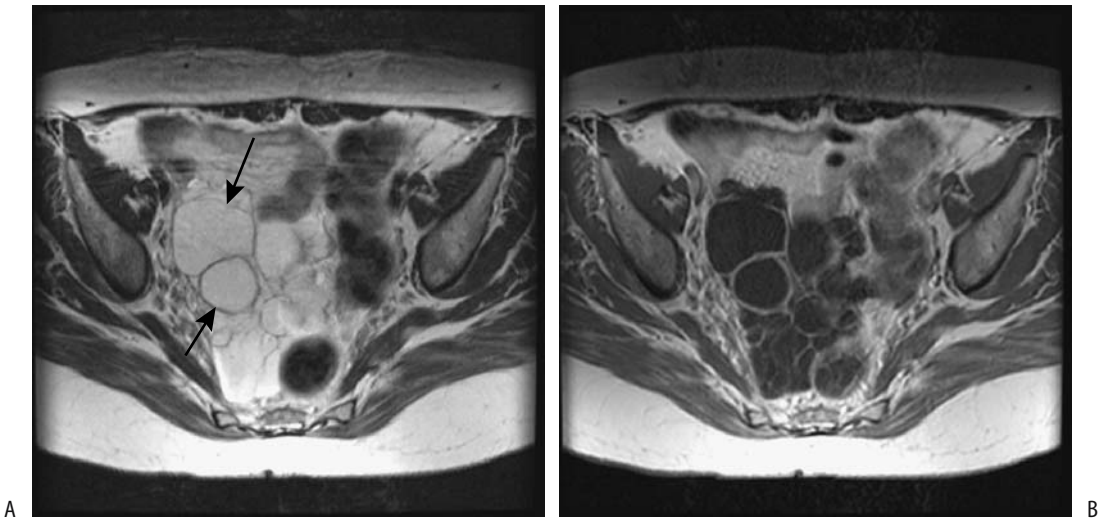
Multicystic mesothelioma. A: Transverse fast spin echo (FSE) T2-weighted MR image shows a pelvic tumor containing a hyperintense signal (arrows). B: Contrast-enhanced T1-weighted image reveals enhancement only in the solid component and septa of this multicystic tumor. (Source: Szklaruk J, Tamm EP, Choi H, Varavithya V. MR imaging of common and uncommon large pelvic masses. *RadioGraphics* 2003;23:403–424, with permission from the Radiological Society of North America.)
